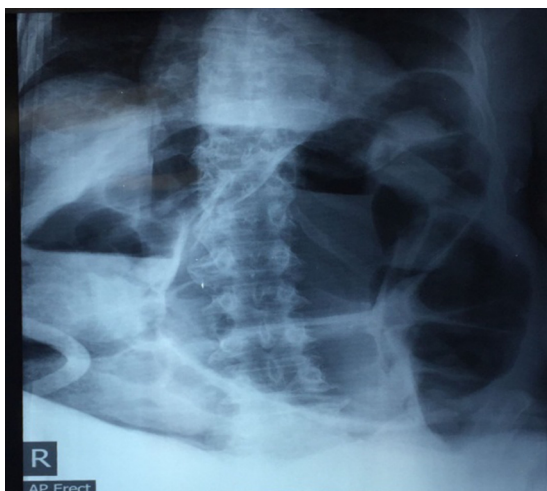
Abdominal X-ray showing Sigmoid Volvulus with Steel pan pattern.
